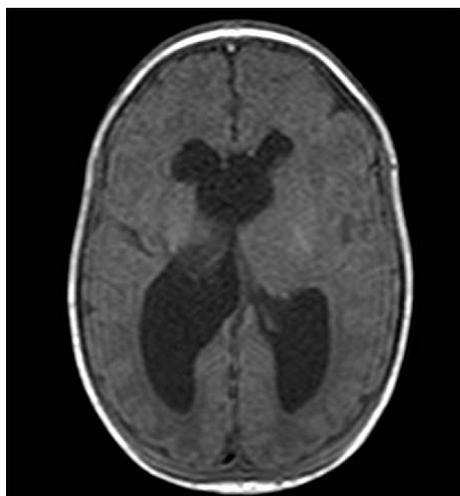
Cranial magnetic resonance imaging on Day 39. T1-weighted imaging shows enlarged lateral ventricles with irregular walls.
